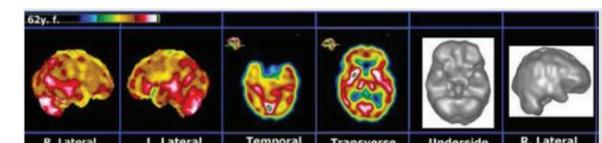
SPECT brain images before and after CTK therapy. Five months after CTK therapy (30 sessions) a marked improvement in perfusion across all cortical and subcortical structures. This corresponded to a dramatic clinical improvement sustained at 3-year follow up.
